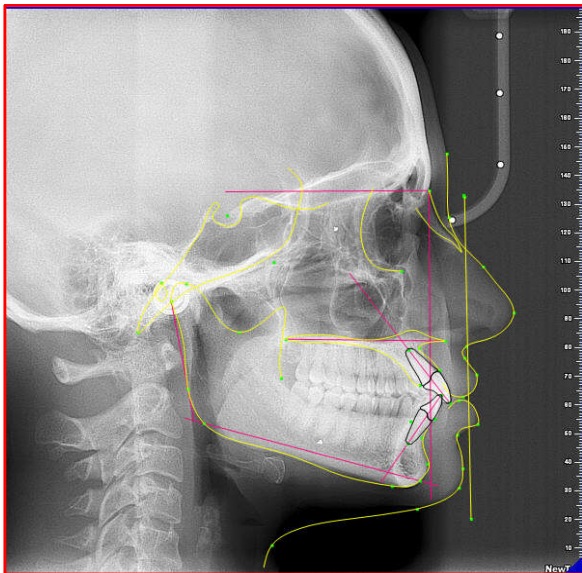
Cephalometric tracing of skeletal analysis (SCA) & soft-tissue analysis performed on radiograph (rSTCA)
